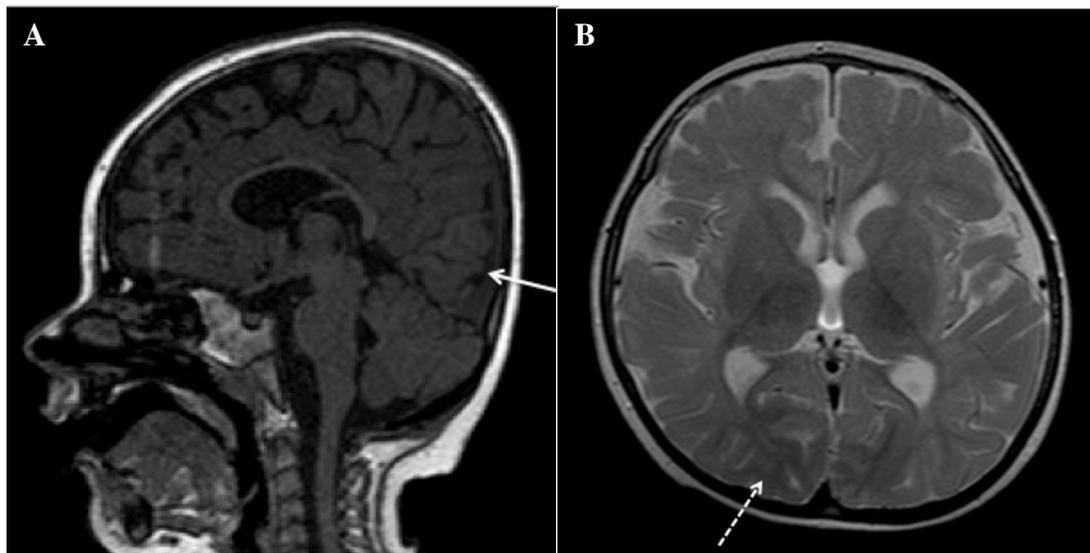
MRI obtained at 2 11/12 years of age. Sagittal T1-weighted image (WI) (A) shows thin corpus callosum and small occipital lobe (thin arrow, A). Please note that the vermis is well-developed. Axial T2WI (B) shows delayed myelination, while it's well observed in the occipital lobe (dashed arrow, B).
